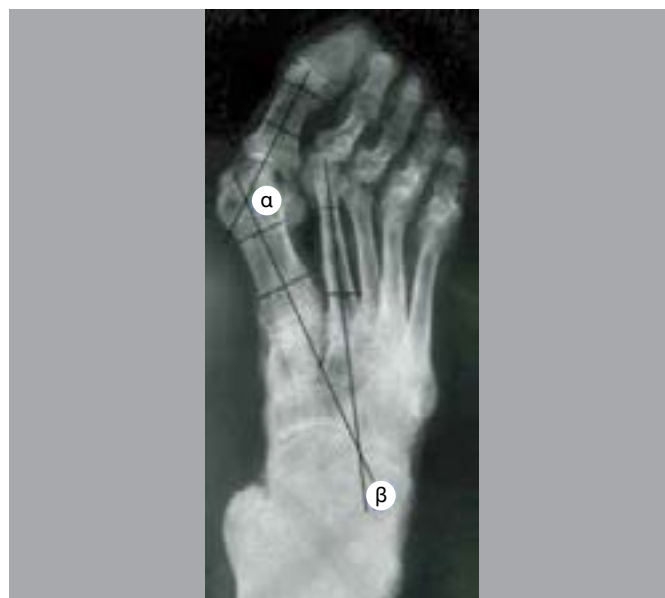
Anteroposterior radiograph of a deformed foot, showing the lines drawn for angle measurements. α = hallux valgus angle and β = intermetatarsal angle.
